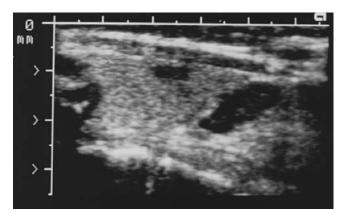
Preoperative sonogram suggestive of a right-sided parathyroid adenoma.
